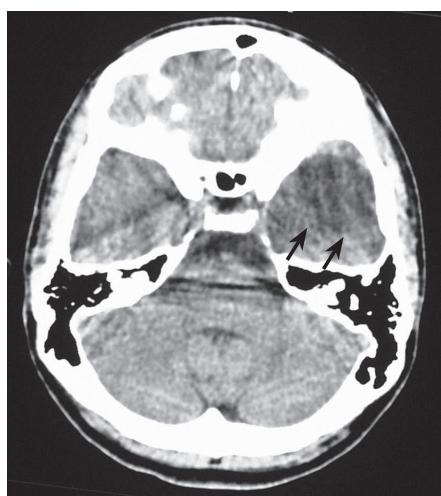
Follow-up CT section shows well circumscribed hypodense lesion in the left middle cranial fossa (arrows).
